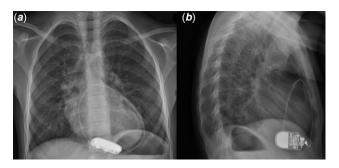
Last posteroanterior (a) and lateral (b) routine chest radiographs before the cardiac arrest. Note the pacing wire posterior looping around the heart.
